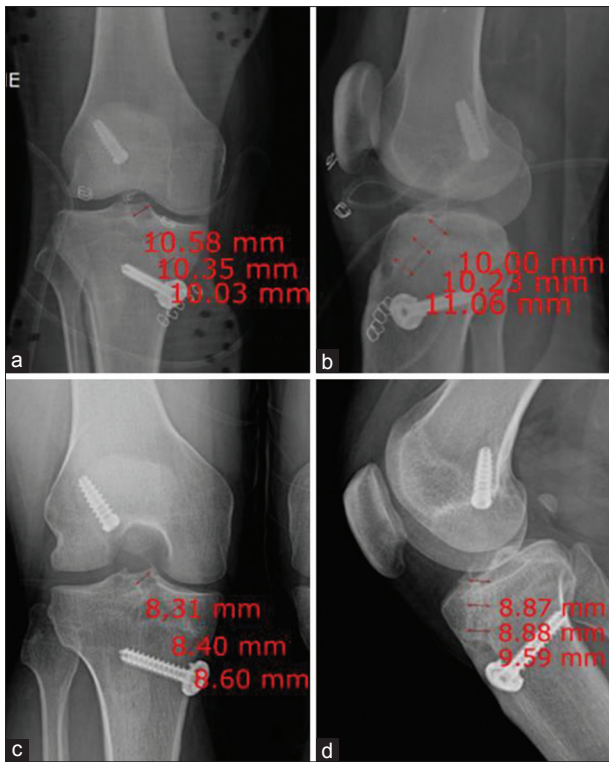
A 31-year-old male patient underwent anterior cruciate ligament reconstruction in our institution using the allo-Achilles graft. (a and b) X-ray of knee joint anteroposterior and lateral views showing the margins of the femoral tunnel could not be identified on postoperative day 1. The tibial tunnel diameters were 10.6, 10.4, and 10.0 mm (proximal, middle, and distal, respectively), and 10.0, 10.2, and 11.1 mm. (c and d) X-ray of knee joint anteroposterior and lateral views showing after 31 months, we could again not find the femoral tunnel margin and the diameters of the tibial tunnel had decreased (8.3, 8.4, 8.6, 8.9, 8.9, and 9.6 mm, respectively)
